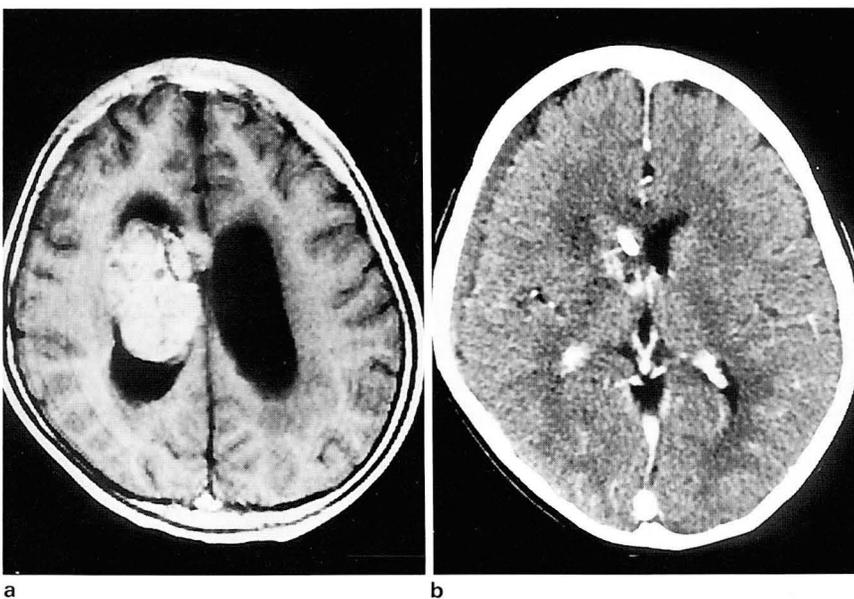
Postcontrast MR imaging(a) 1 year following radiotherapy demonstrated a new, large enhancing tumor in the right lateral ventricle with an exophytic component and severe obstructive hydrocephalus. Postcontrast CT scan(b) 5 weeks following the second radiotherapy demonstrates marked decrease in size of the tumor and hydrocephalus. Subdural fluid collection along right frontotemporal region is also seen.
